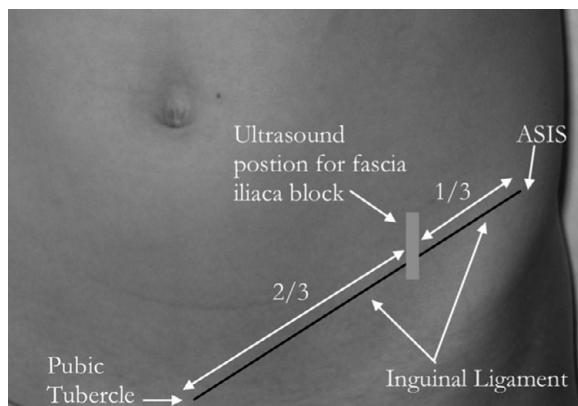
Anatomic placement of the ultrasound probe (grey box) one-third the distance from the anterior superior iliac spine (ASIS) and two-thirds the distance from the pubic tubercle along the inguinal ligament
